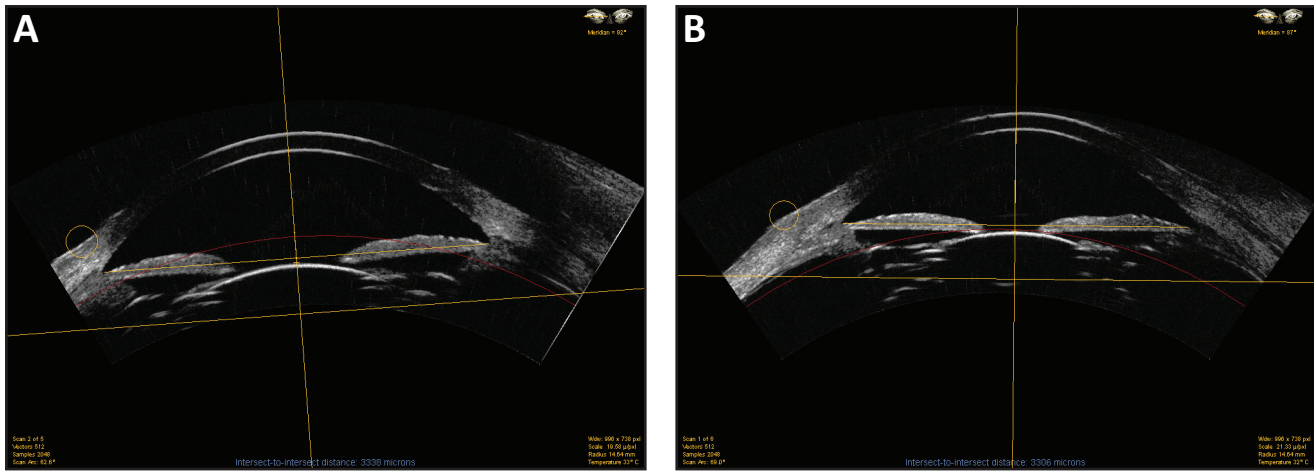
Images of horizontal B-scan with a very high-frequency digital ultrasound arc scanner (Artemis 2, ArcScan, Inc, Morrison, CO) through an eye of a patient with an accommodating intraocular lens (IOL). Images were taken 1 month following surgery, (A) before and (B) after application of 1 drop of pilocarpine 4%. Note the forward movement of the implanted IOL, accompanied by pupil miosis.
